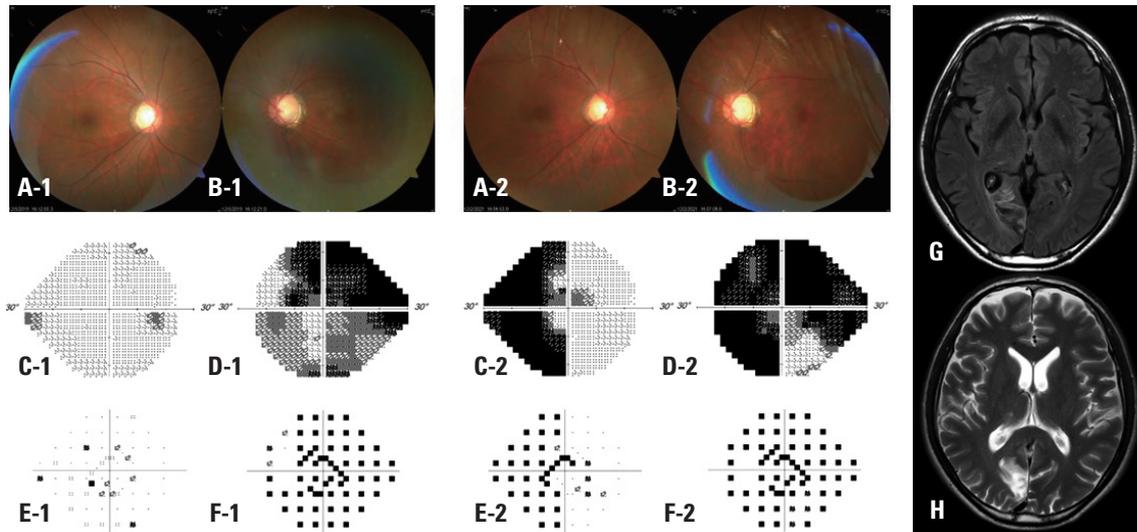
A representative case of a glaucoma patient who showed a significant finding on brain MRI. (A and B) Fundus photographs; (C and D) visual sensitivity maps; (E) pattern deviation map of the right eye; and (F) total deviation map of the left eye. Images obtained in 2019 are labeled “-1,” and those obtained in 2021 are labeled “-2.” (G) T2 fluid-attenuated inversion recovery horizontal brain MRI; (H) T2-weighted horizontal brain MRI. Due to reliability issues, images obtained in 2019 are presented for comparison with those obtained in 2021. A 51-year-old male who had been using IOP-lowering medication for over 6 years for primary open-angle glaucoma in both eyes visited our hospital every 6 months. In 2021, the vertical cup-to-disc ratio was 0.7 in the right eye (A-2) and 0.9 in the left eye (B-2). Compared with his previous visual field test (C-1, D-1, E-1, and F-1), right homonymous hemianopia was identified (C-2, D-2, E-2, and F-2), which prompted brain MRI. MRI showed an old infarct with residual hemorrhage in the right occipital lobe (G and H). Since he had been taking warfarin for aortic graft replacement, regular neuroimaging was recommended. MRI, magnetic resonance imaging; IOP, intraocular pressure.
